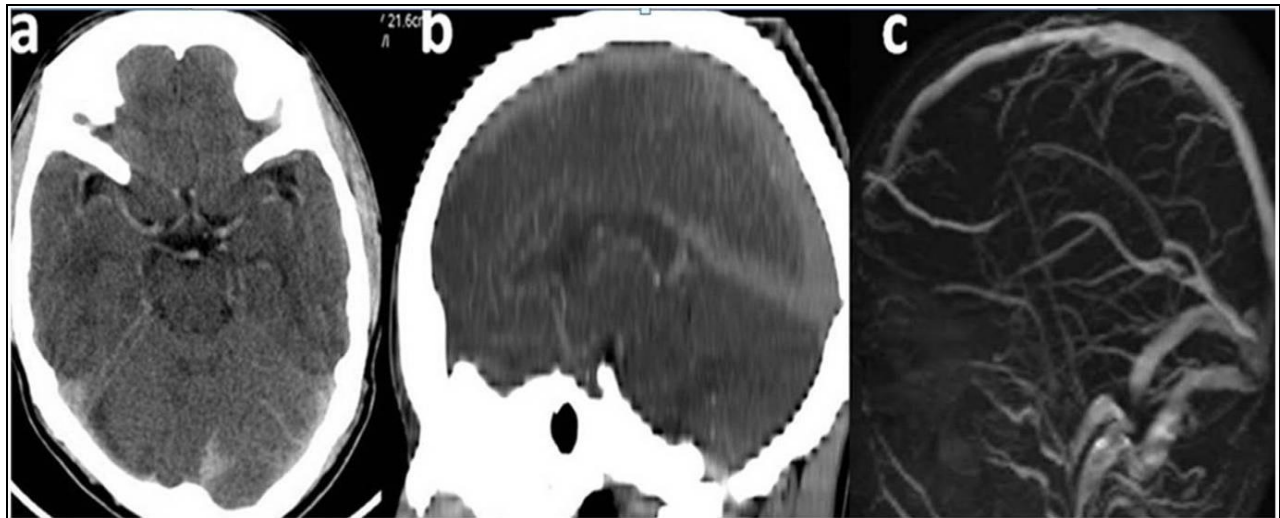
NON-CONTRAST COMPUTED TOMOGRAPHY SCAN OF HEAD SHOWS HYPERDENSE CIRCLE OF WILLIS (a), HYPERDENSE SAGITTAL SINUS AND STRAIGHT SINUS (b). MAGNETIC RESONANCE VENOGRAPHY OF BRAIN SHOWS PATENT VENOUS SINUSES(c).
